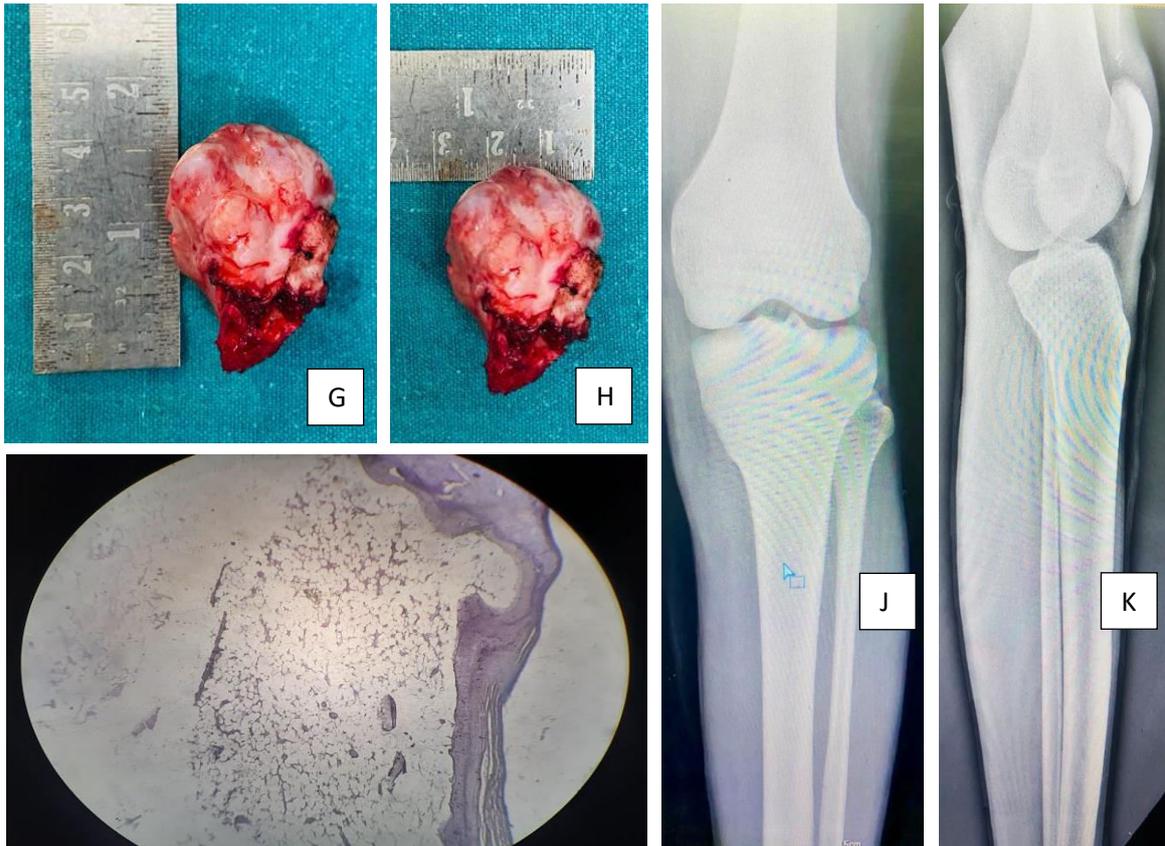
(A)x-ray showing solitary pedunculated exostosis, (B,C)MRI+CT LEFT KNEE shows single osteochondroma with cartilage cap of 1.6mm at antero-medial aspect of proximal tibia, (D)clinically presented as a swelling over medial aspect of proximal part of left leg
